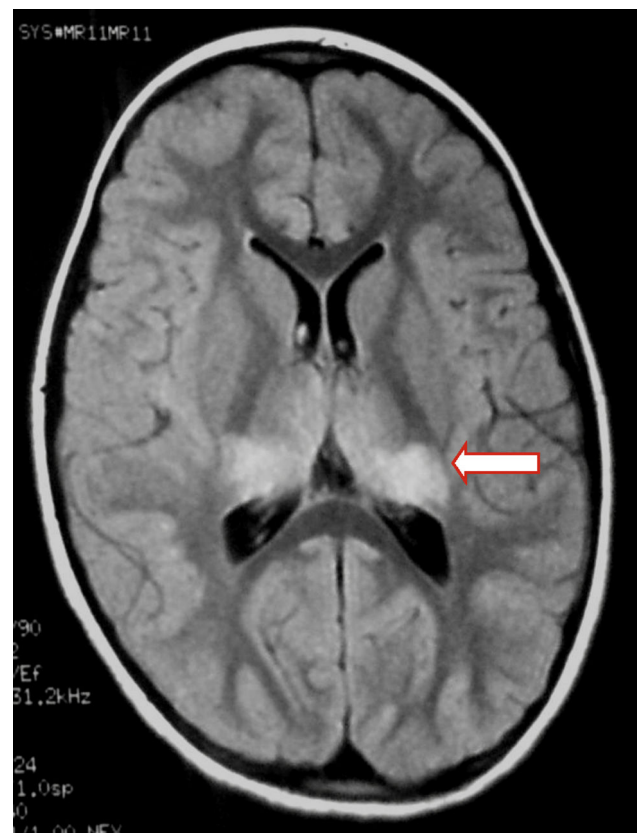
Axial FLAIR MR image: bilateral thalamic hyperintensities.
